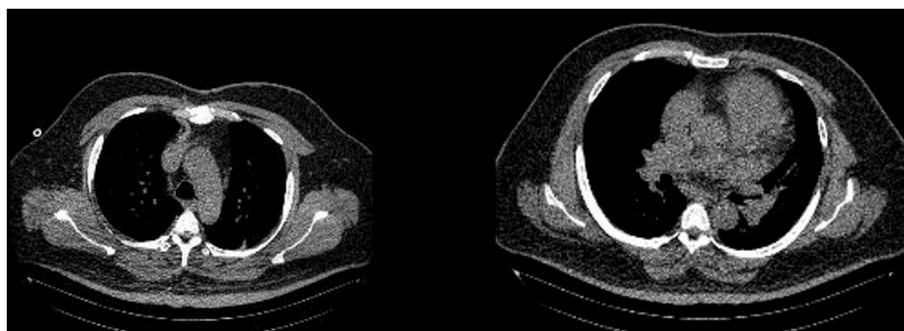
Pre-operative CT imaging of patient's thorax.
